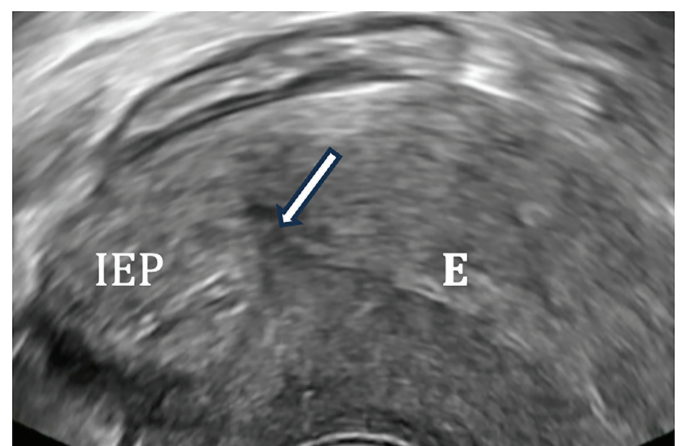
A B-mode ultrasound image of the uterus in the transverse plane. A thin interstitial tube (arrow) is seen adjoining the endometrial cavity (E) and a right interstitial ectopic pregnancy (IEP).
